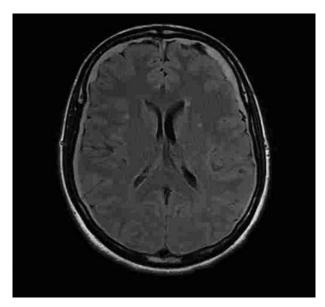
Axial FLAIR MRI sequence shows subdural effusion.
